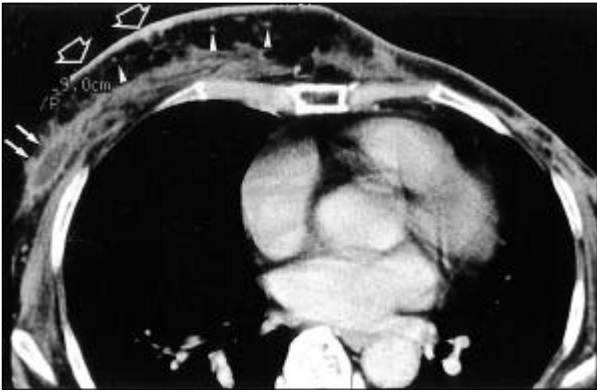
Lymphangitic metastasis to the contralateral breast following left modified radical mastectomy due to breast cancer in a 63-year-old woman. On chest CT, the right breast shows diffuse skin thickening (open arrows), several tiny nodules (arrow heads) in the subcutaneous layer, and loculated fluid collection of unknown origin (arrows).
